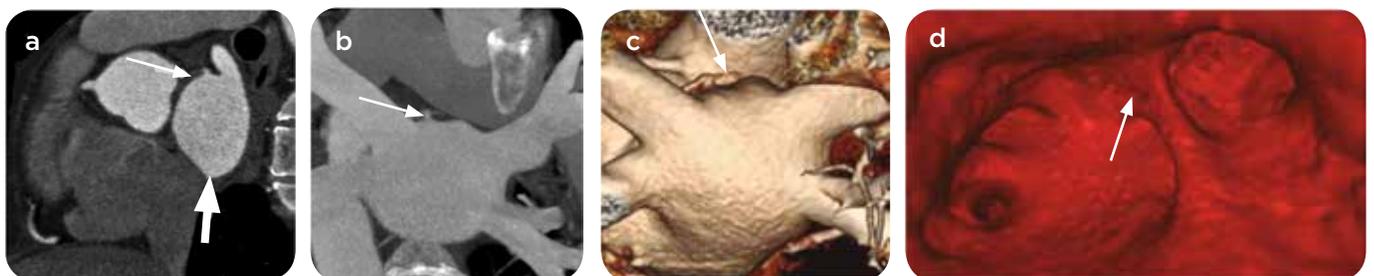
45-year-old patient with paroxysmal atrial fibrillation, with diverticulum and accessory auriculum of the left atrium as incidental findings in a triggered cardio CT study for mapping of pulmonary and left atrial veins. Multiplanar reconstructions: a) sagittal, b) coronal; Three-dimensional reconstructions: c) epicardial and d) endocardial left atrium. The accessory auriculum (arrows) of the upper left atrial wall, with narrow neck and irregular contours are identified by the pectine muscles and diverticulum in the lower, broad-walled, smaller, smooth-walled wall (white arrow).
